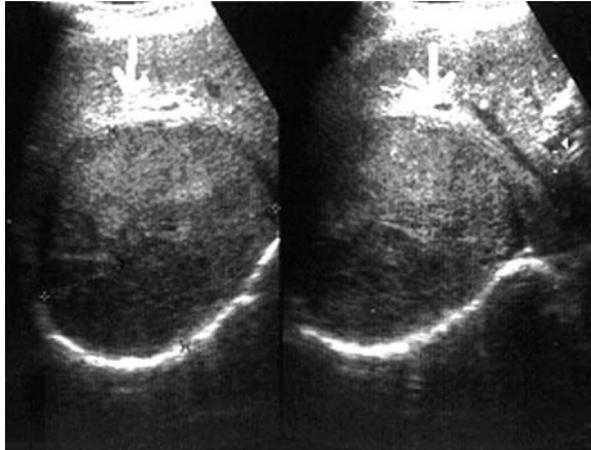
Peripheral capsulated mass on ultrasonography
